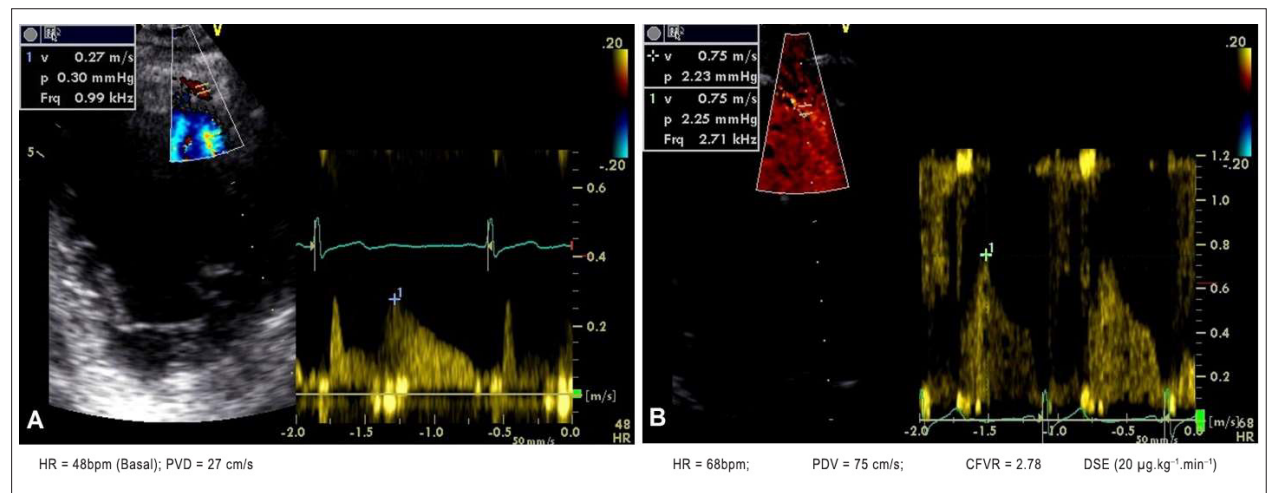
Male patient with target heart rate (HR) of 142 bpm. Figure 1A shows Doppler assessment in the left anterior descending coronary artery (LAD) at baseline. Figure 1B, during dobutamine stress echocardiography (DSE), dose = 20 µg.kg⁻¹.min⁻¹ and HR = 68 bpm, shows normal (=2.78) and early (obtained before achieving target HR) coronary flow velocity reserve (CFVR). Normal left ventricular contractility during the entire exam.
